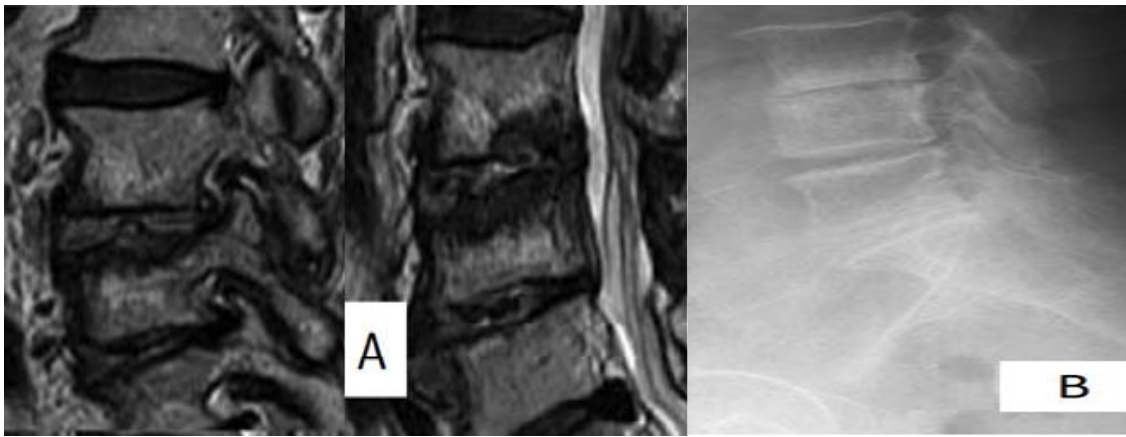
Preoperative A: MRI, B: X-ray of male patient 52 years old with L4-L5 Spondylodiscitis. VAS score on admission was 8. Frankle scale was C preoperatively. And ODI was 82%.
